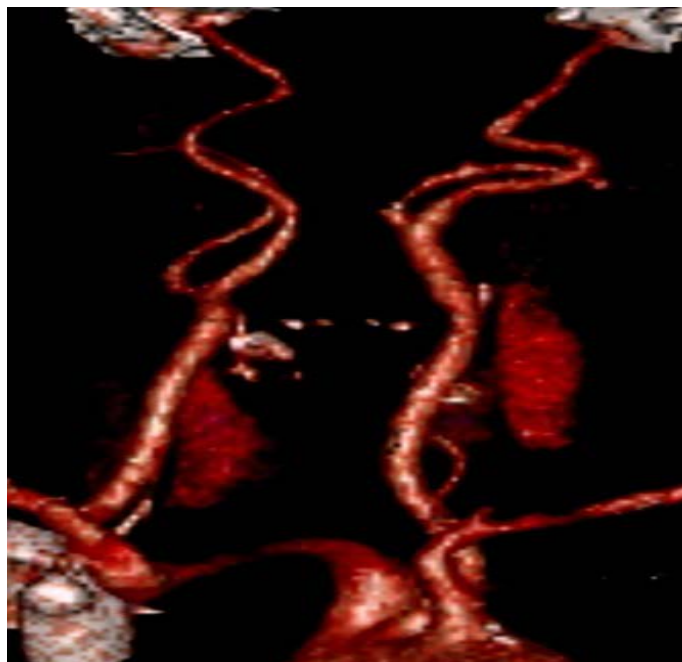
CT MIP images showing the abnormal medial course of carotid arteries on both the sides.
